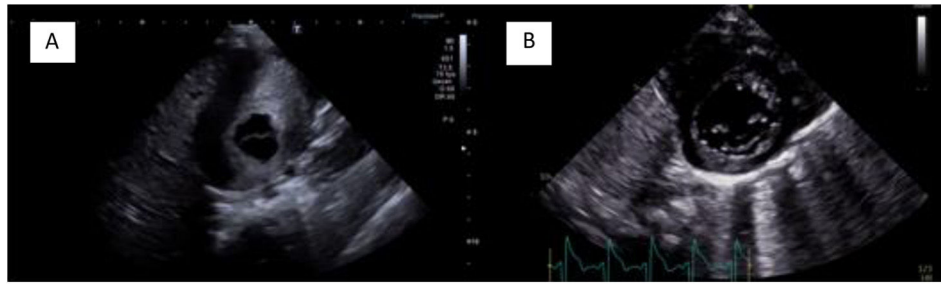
(A) Pretreatment parasternal short-axis view. (B) Post-treatment parasternal short-axis view.
